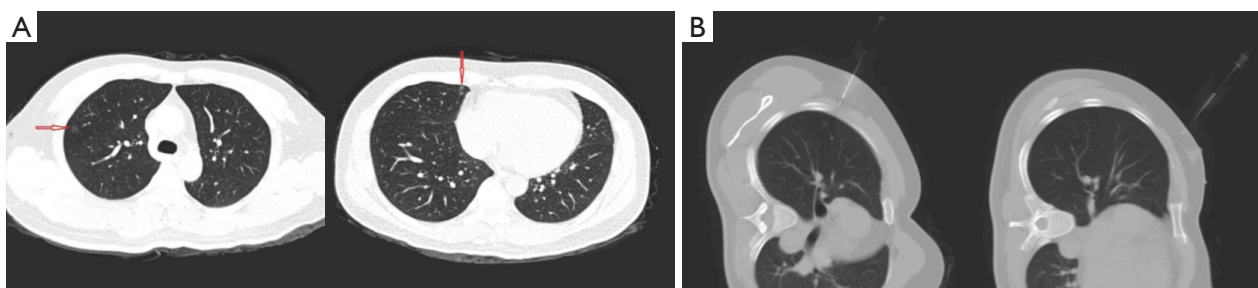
CT images of lung before and during puncture. (A) CT scan of the chest before puncture, with nodules in the middle and upper lobes of the right lung indicated by red arrows. (B) CT scan of the chest during puncture, with the needle observed to be white. CT, computed tomography.
